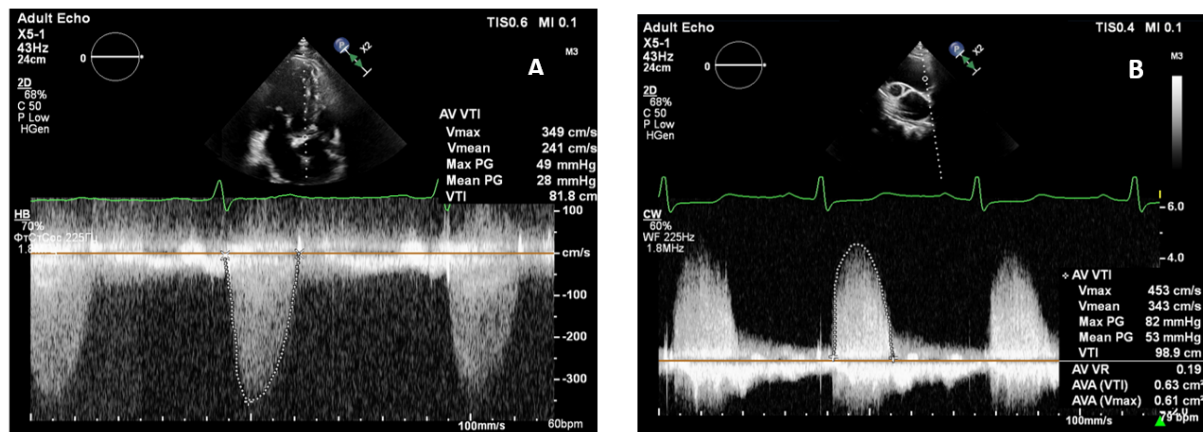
Reclassification of aortic stenosis severity in one patient. (A) Apical window pressure gradients corresponding to moderate stenosis, (B) right parasternal window pressure gradients corresponding to very severe stenosis.
